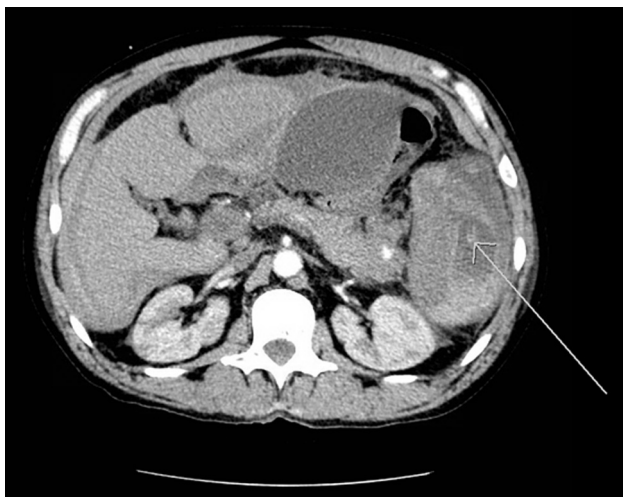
Contrast-enhanced computed tomography abdomen demonstrates a small area of contrast extravasation (arrow) in an enlarged, heterogeneous spleen with multiple areas of parenchymal devascularization. Hemoperitoneum was also evident.
